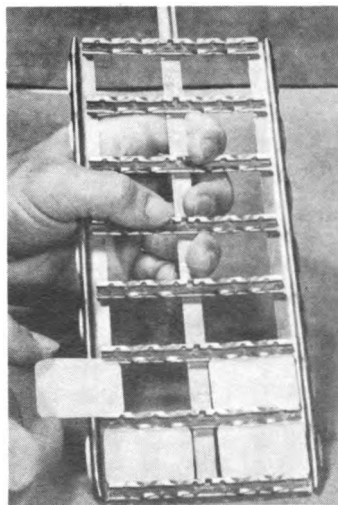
Film holder for processing periapical and bitewing films.
